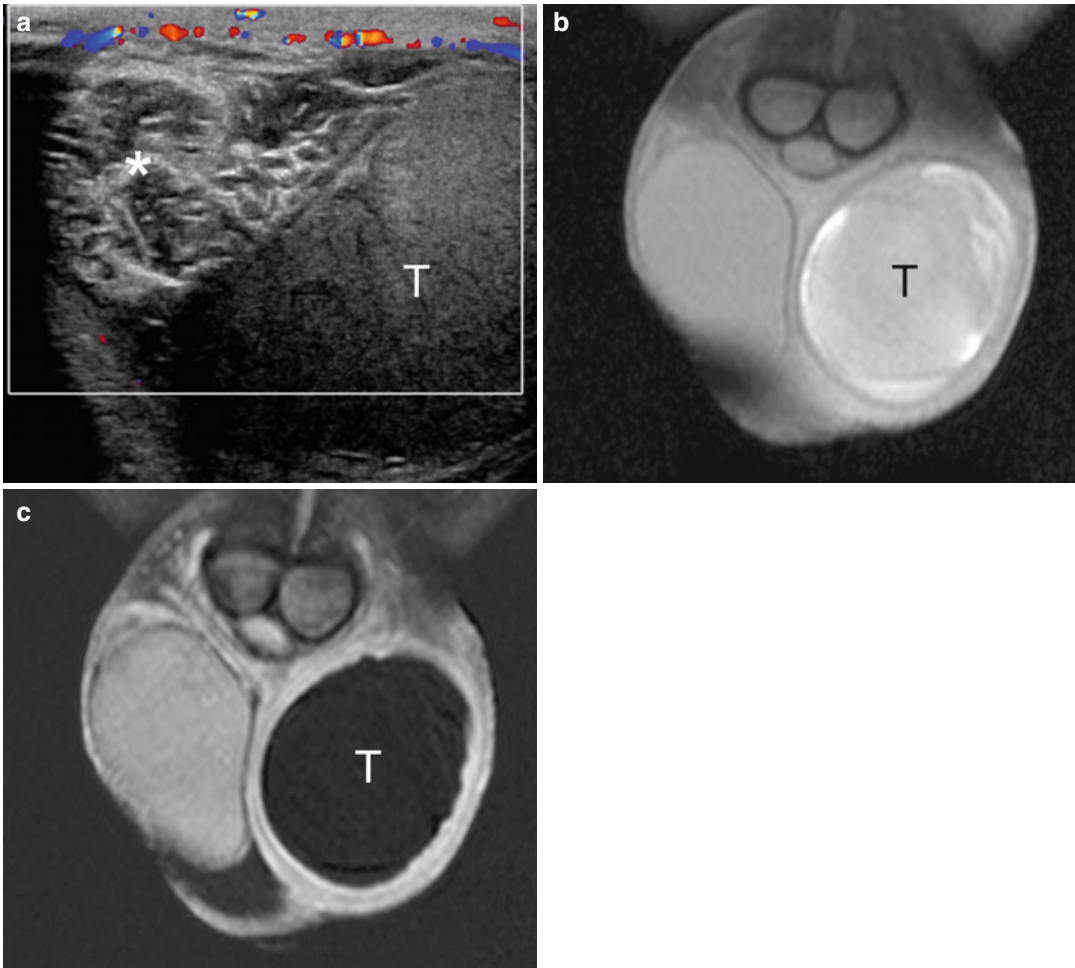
Long-standing high-degree left testicular torsion. (a) Color Doppler interrogation shows an avascular left testis (*T*) and a twisted spermatic cord (*asterisk*). The paratesticular tissues display increased vascularization. (b) T1-weighted coronal image with fat suppression
